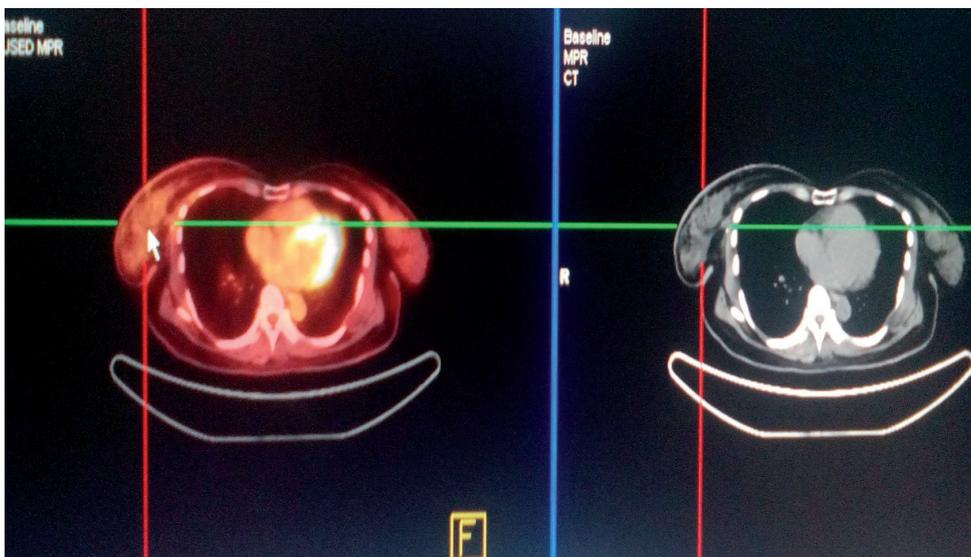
Axial PET-CT and CT images of patient categorized as a false positive.
